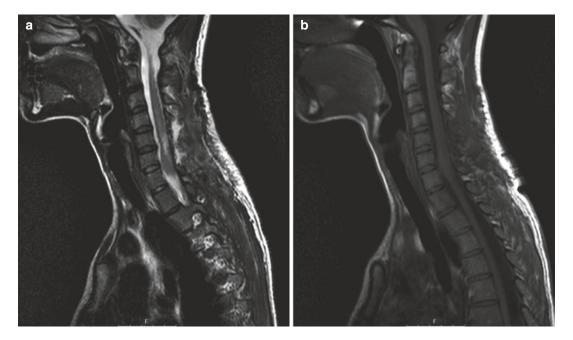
Postoperative MRI scan I. The MRI scan shows postoperative sagittal T2 (a) and contrast T1 (b) rendering gros total tumor resection
